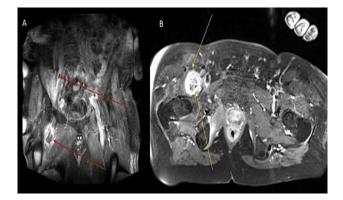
MRI images demonstrating (A) right sided IPA (red arrow) and (B) inflammation of the proximal right femur (yellow arrow).
